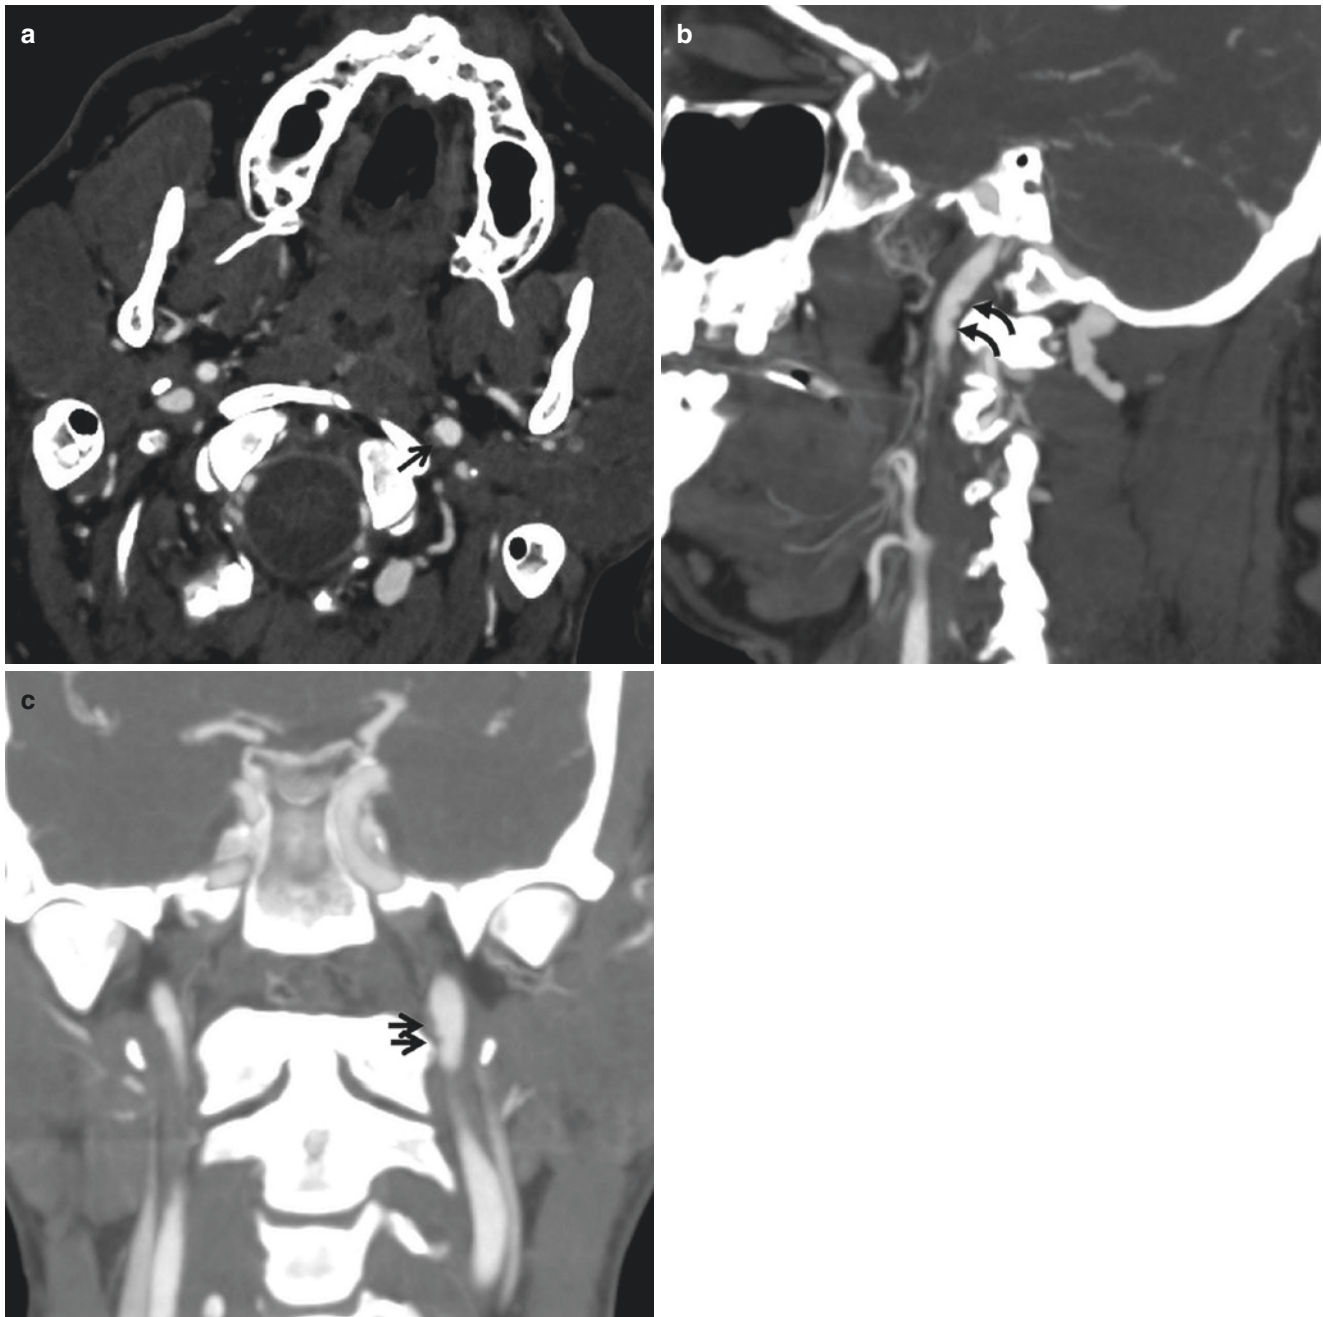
Grade I ICA injury. Axial CTA of a patient with motor vehicle collision demonstrates minimal contour irregularity and wall thickening of left cervical ICA at the level of C1 (*arrow*) with less than 25%
